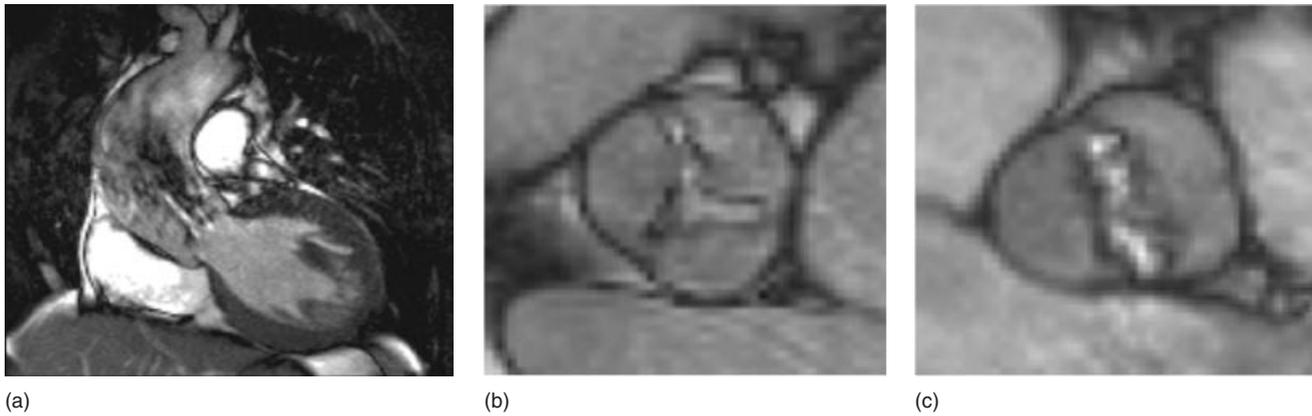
Cardiac magnetic resonance imaging in aortic stenosis. (a) A narrow high-velocity jet in the left ventricular outflow tract; (b) 'en-face' view of a stenosed trileaflet aortic valve; (c) 'en-face' view of a stenosed bicuspid aortic valve.
